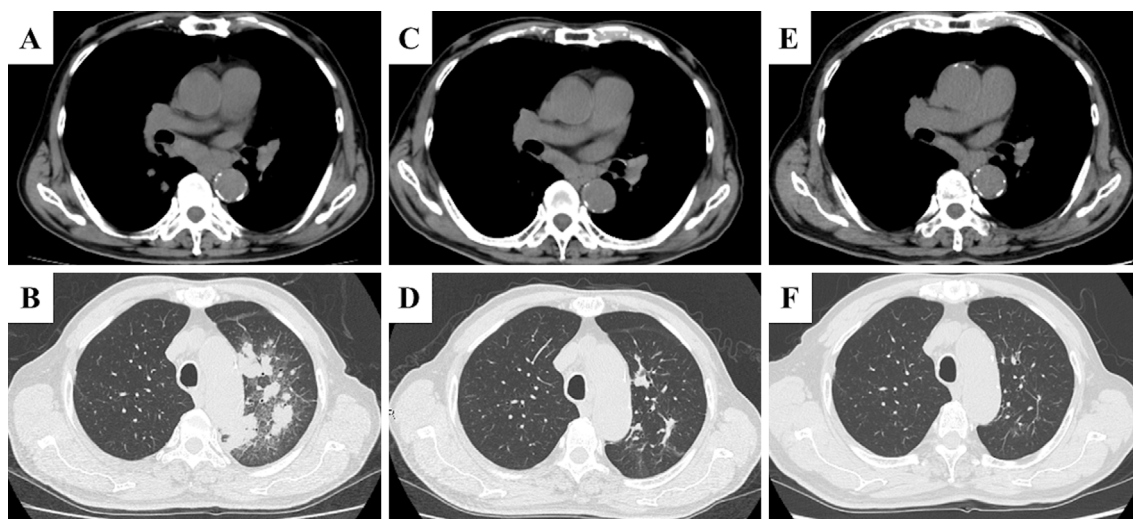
A computed tomography (CT) scan revealed diffuse infiltrates in the left lung after treatment with fluconazole and voriconazole (A, B). CT scans conducted 2 months (C, D) and 12 months (E, F) after the administration of amphotericin B and flucytosine revealed that diffuse infiltrates in the left lung had diminished, and the size of the subcarinal mediastinal lymph node had decreased.
